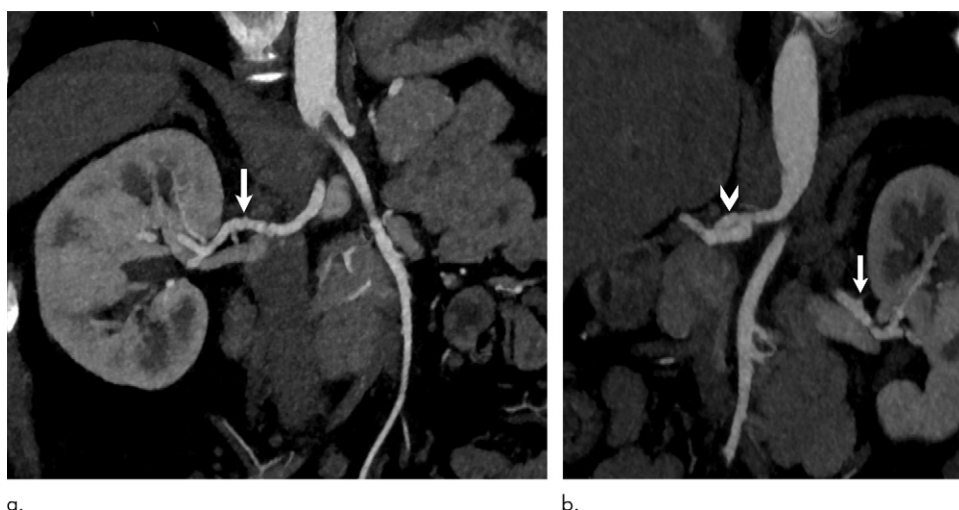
Maximum intensity projection images from CT angiogram of the same patient as Figure 3 (42-year-old woman) show beading of the (a) right and (b) left renal arteries (arrow). (b) Focal dissection and beading (chevron) of celiac artery is also seen.
